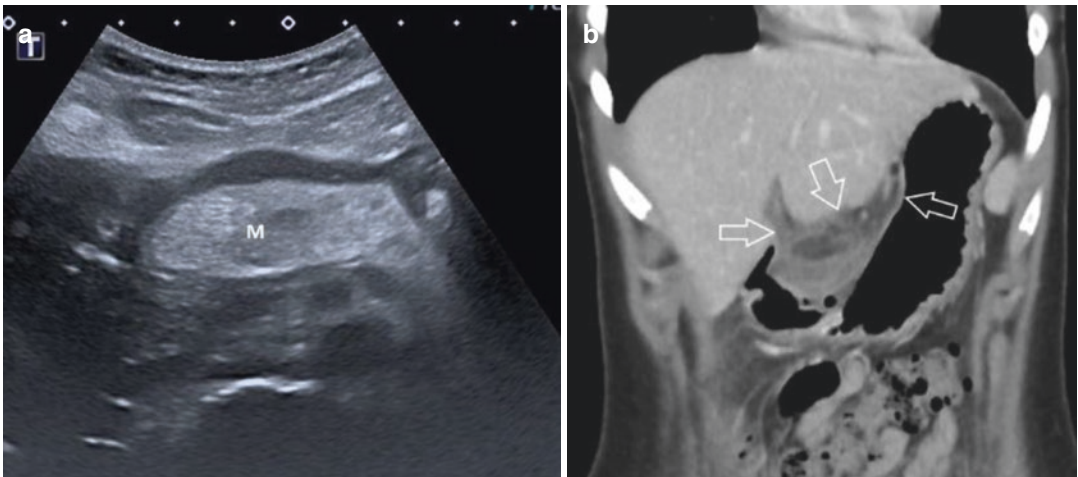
Infarct of the lesser omentum in a 14-year-old teenage girl. (a) US Transverse scan of the epigastric area showing an oval hyperechoic mass. (b) CE-CT Venous phase; hypodense area below the margin of the liver surrounded by inflammatory reaction
